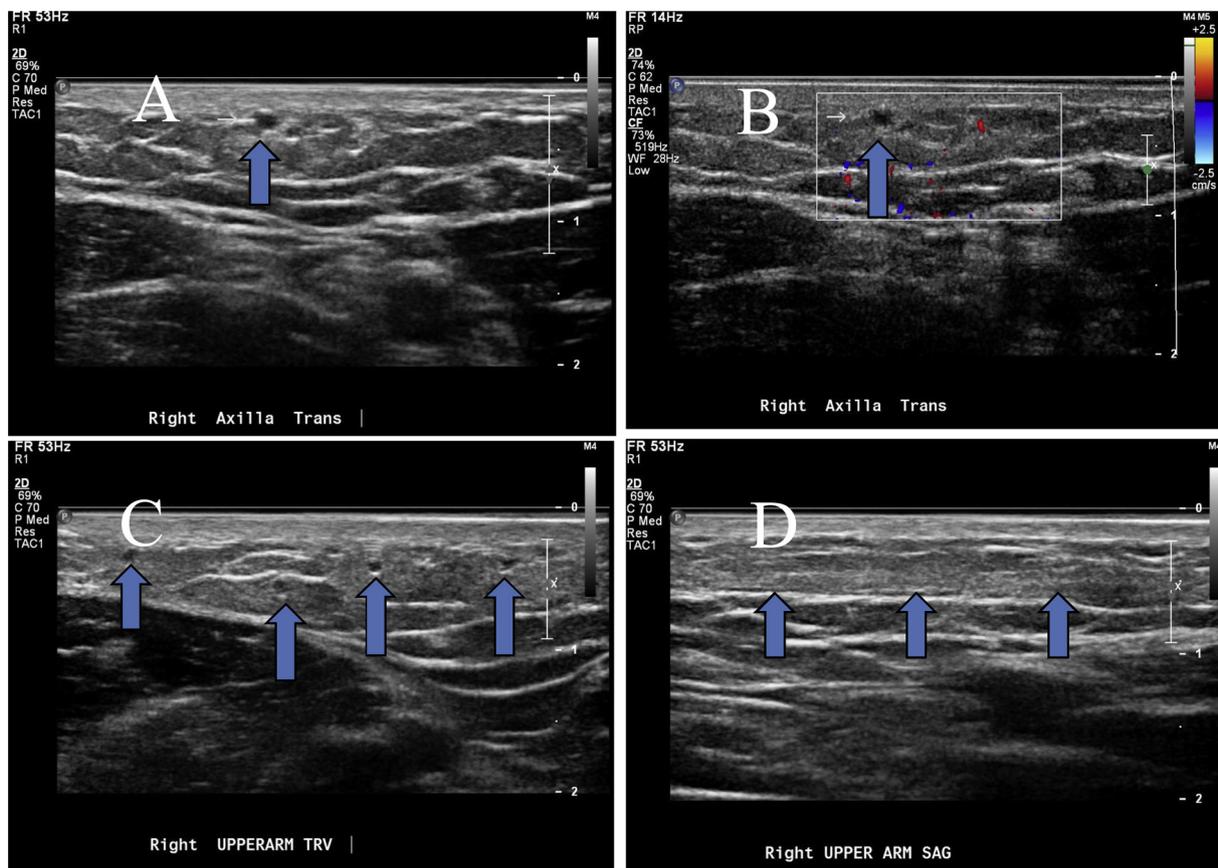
Ultrasound images of the 75-year-old man in Fig. 2. A: transverse view of cord in axilla, B: color Doppler image shows no flow in cord, C: transverse image of multiple cords in the upper arm, D: increased echogenicity of subcutaneous fat.
